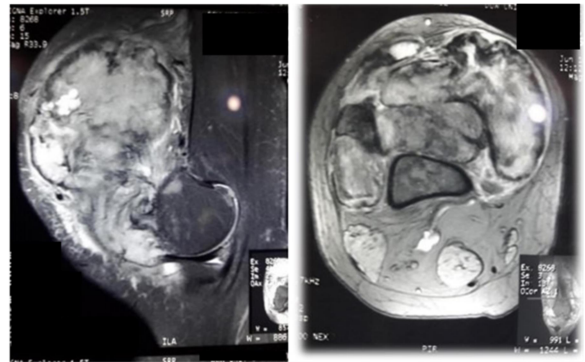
MRI of right knee joint coronal and transverse slices showing GCT of patella with tumor extension into quadriceps tendon and muscles superiorly, infrapatellar tendon and fat pad inferiorly, lateral retinaculum laterally, medial retinaculum medially, and femorotibial space posteriorly.
